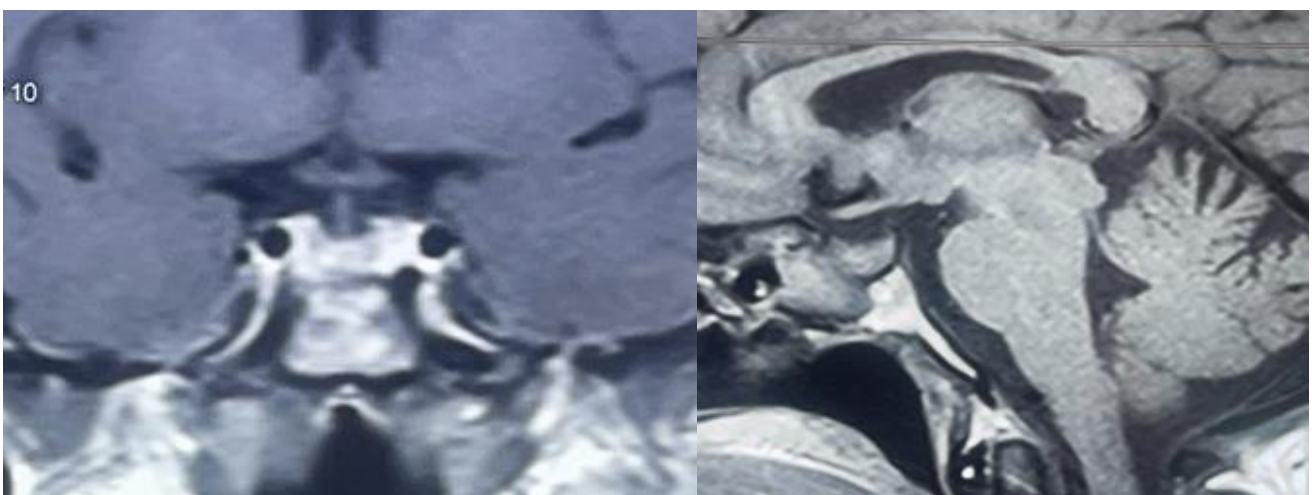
Post-operative sagittal and coronal hypothalamic-pituitary MRI showing no abnormalities or signs of recurrence
